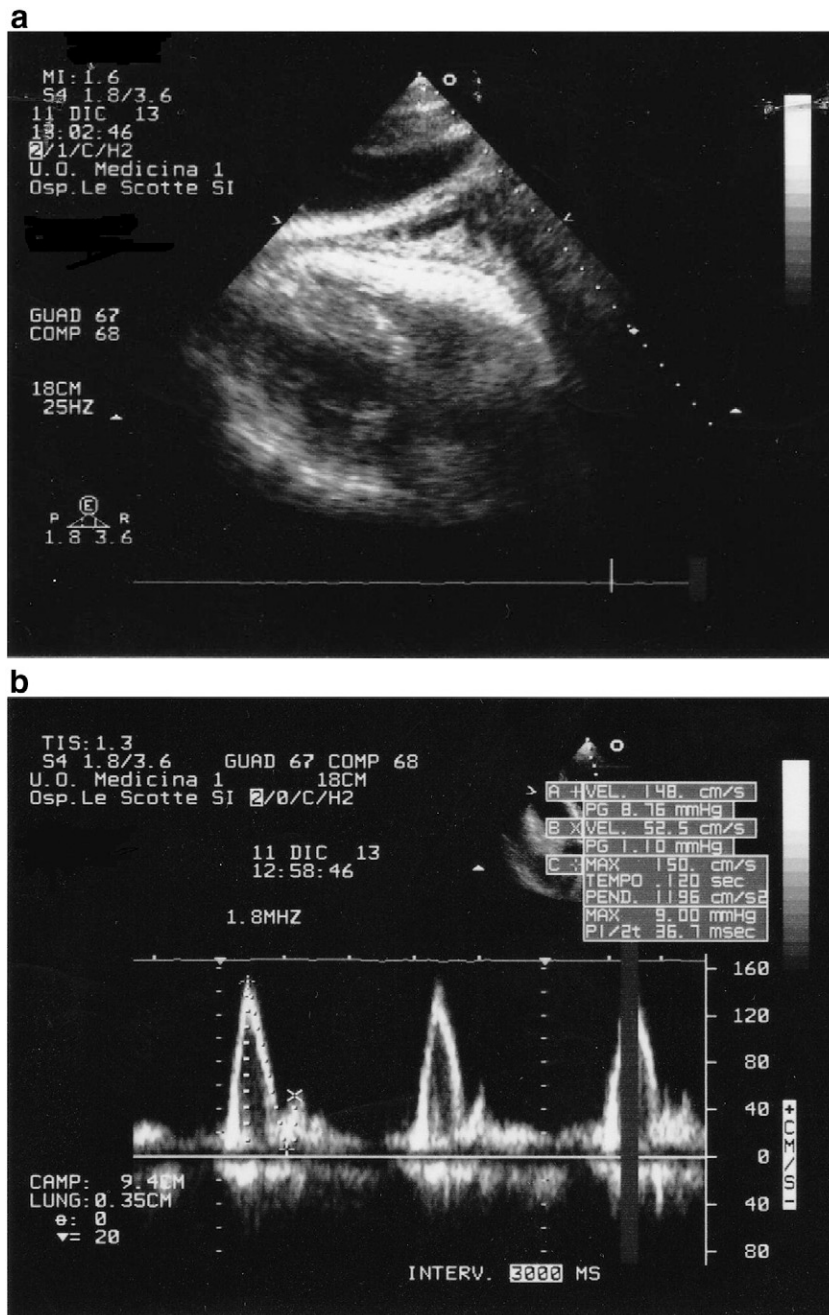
Pericardial thickness associated with fibrinic material deposition and adherences between internal and external leaflets (a); pattern Doppler of transmitral flow demonstrating a classical “restrictive filling pattern” with increased E/A ratio and reduced deceleration timing (b).
